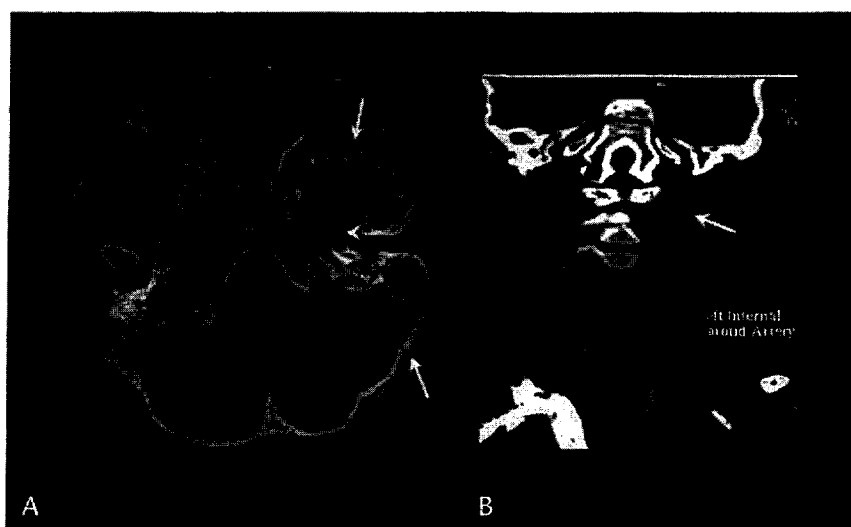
Images obtained from a 5-year-old boy. A, Computed tomographic image shows left-side skull base fractures involving left-side occiput, petrous bone, and sphenoid wing (arrows). Air densities are seen within the carotid canal (arrowhead). B, Computed tomography angiogram shows left-side cervical internal carotid arterial dissection with marked luminal narrowing (arrow).
